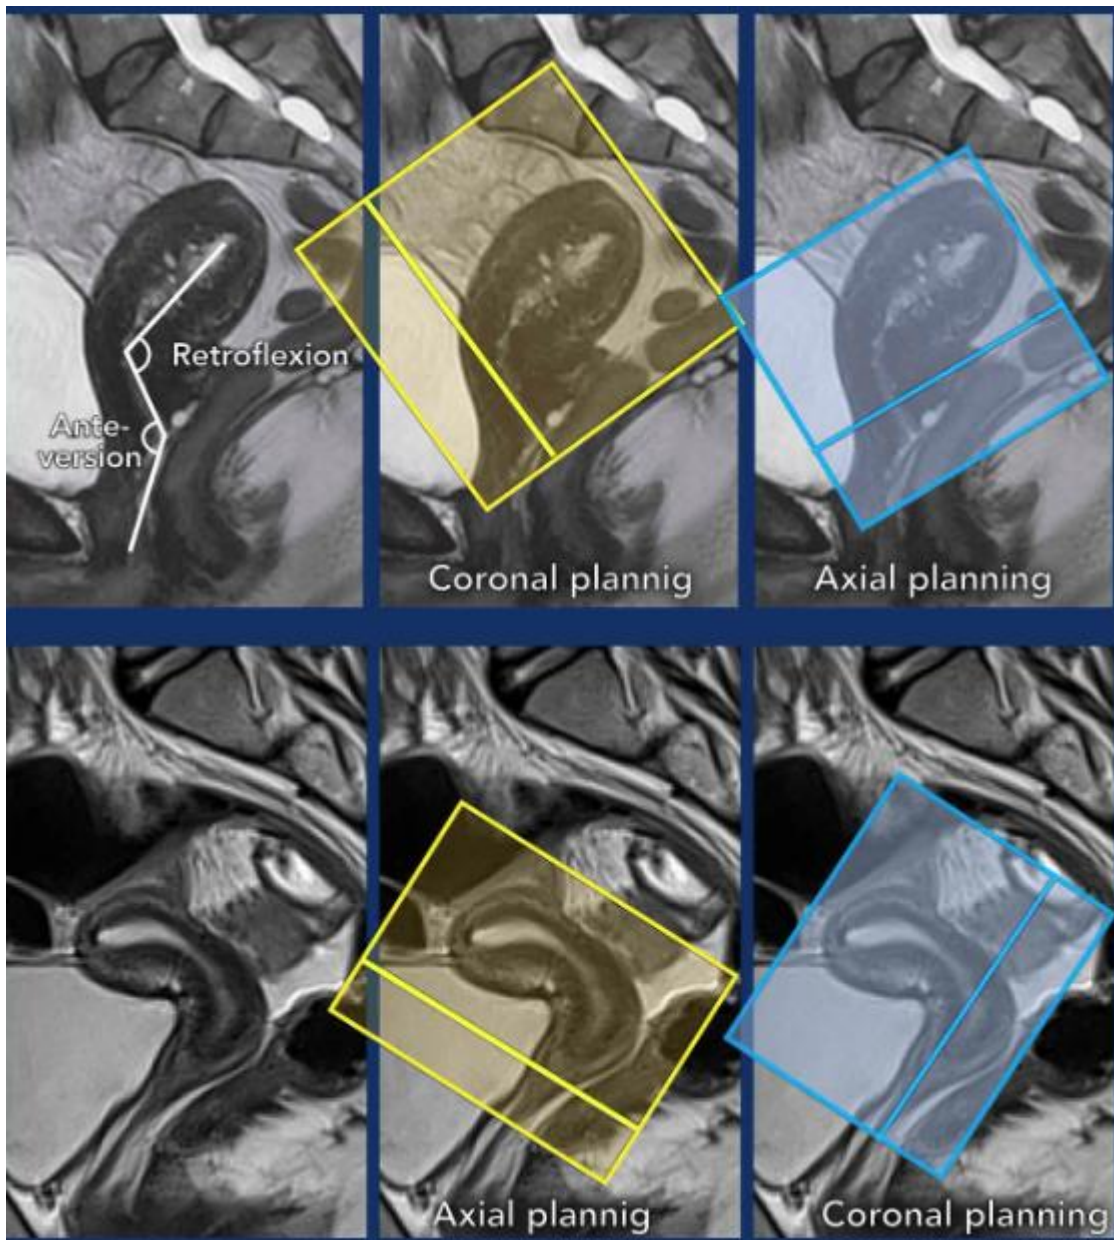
shows the MRI sequence planning in MRI pelvis for cervical imaging in axial and coronal planes.
